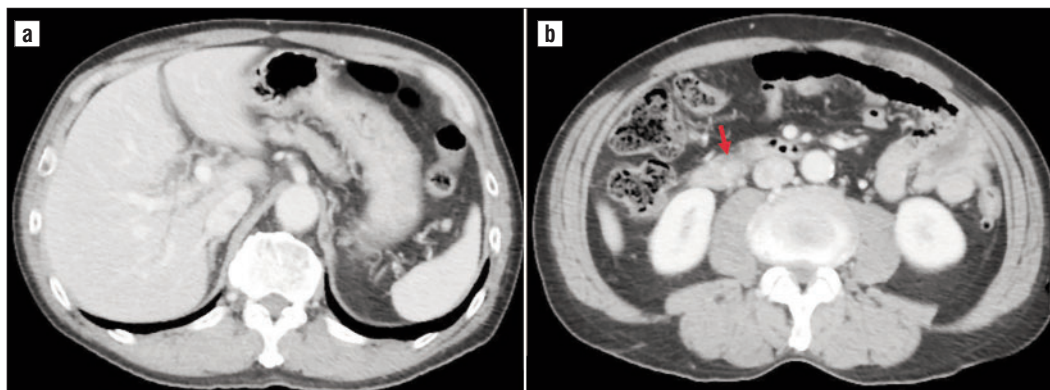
Abdominal computed tomography. (a) Abdominal computed tomography detects dilation of an intrahepatic bile duct. (b) A nodular shadow is seen in the distal bile duct (→).
